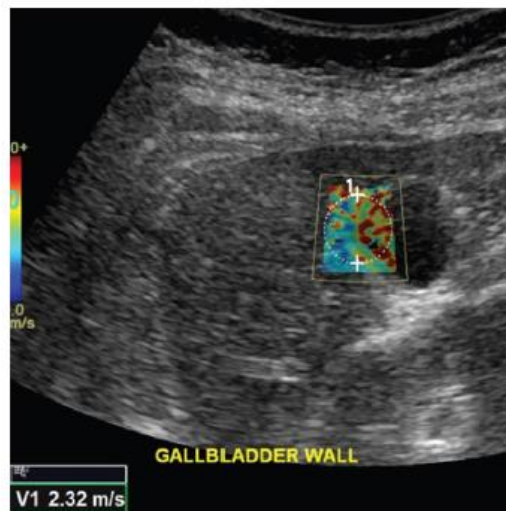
An ultrasound elastography study of a 62-years-old lady with hepatitis C and cirrhosis <sup>(9)</sup>.
